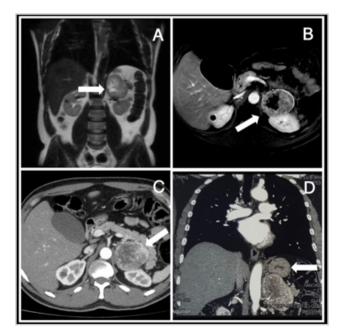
A, B: An abdominal MRI in the arterial phase. C: A triphasic abdominal CT. D: CT angiography of the chest showing a heterogenous left adrenal mass with areas of necrosis and hemorrhage, measuring 66.5 mm x 60.9 mm.
